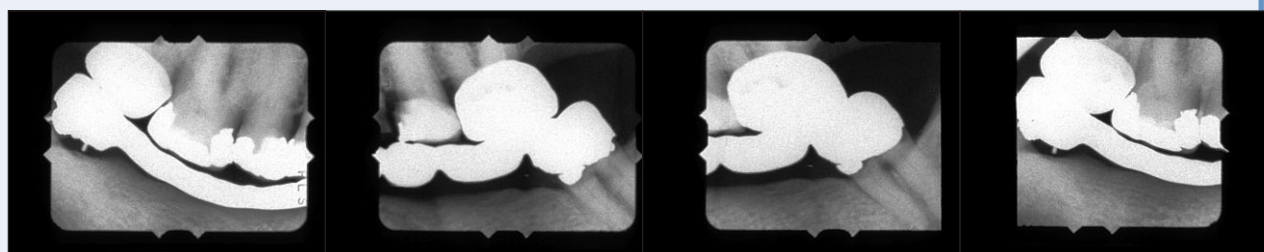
Bitewing radiographs of the patient showing the long-span fixed partial dentures with caries in the abutment teeth.
